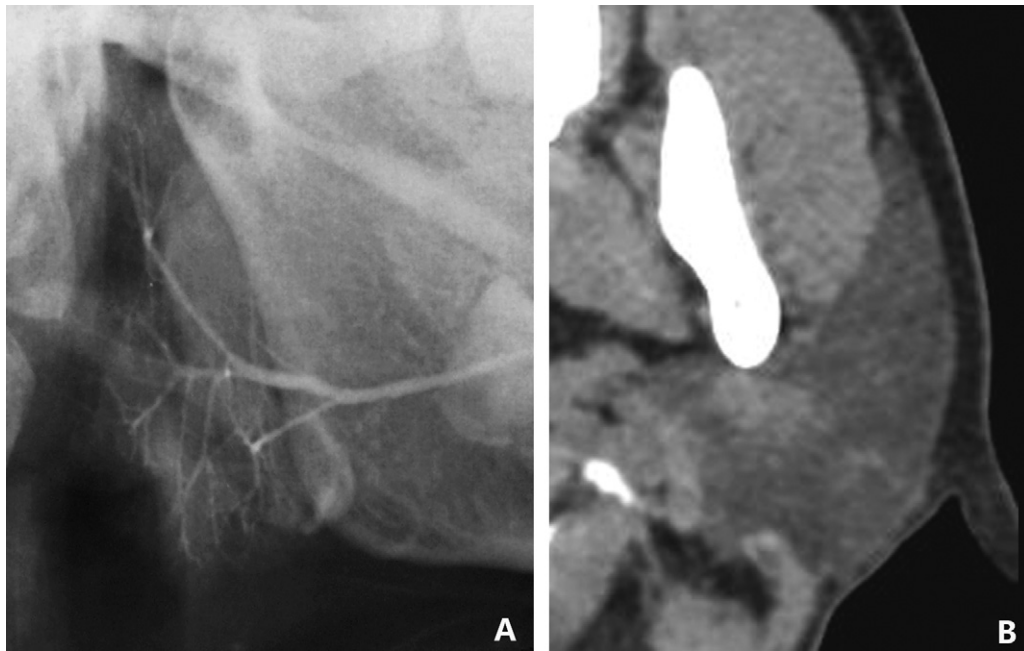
Normal manifestations of sialogram and CT of parotid gland. Note the absence of sialectasia in the sialogram (A) and homogeneous attenuation of the parotid gland in CT (B) in the same patient (50-year-old, female).
